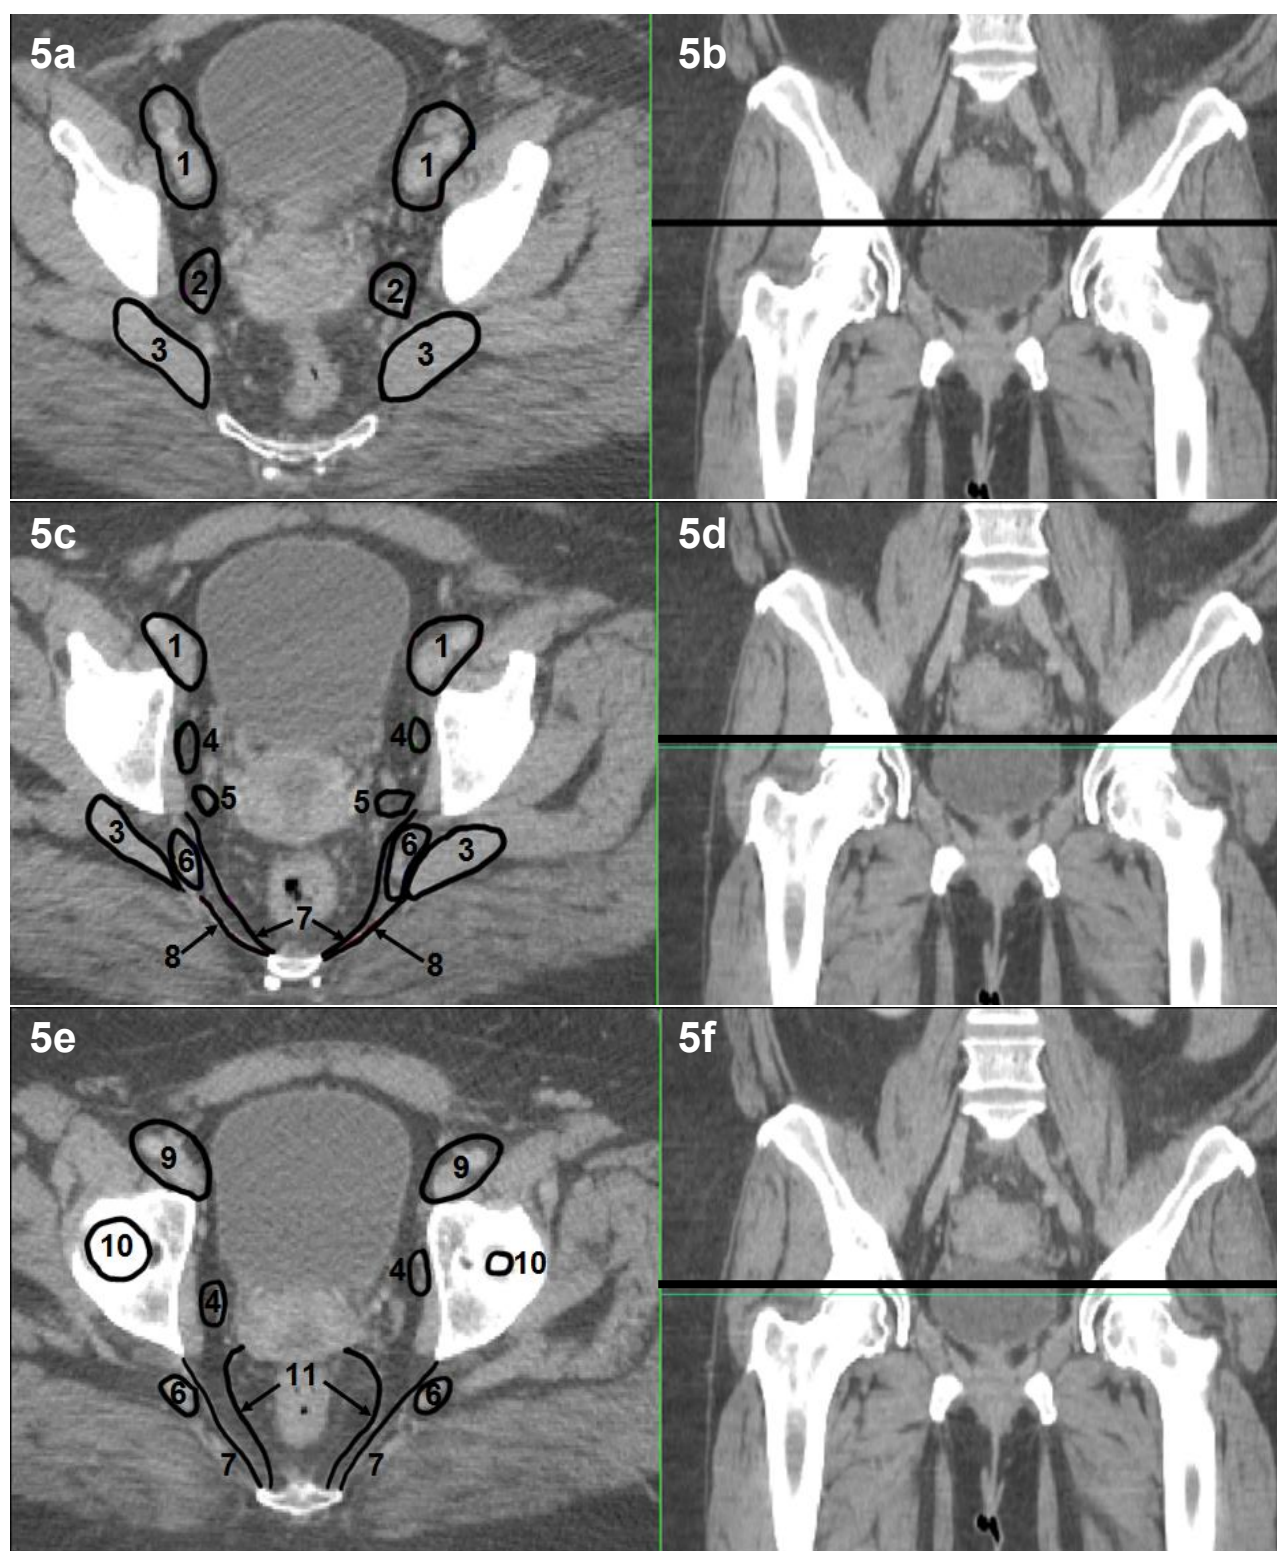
Transverse pelvic CT images (a,c,e) with the corresponding level shown on the coronal images (b with a, d with c and f with e). Anatomical areas: 1=external iliac vessels; 2=junction of gluteal and internal iliac vessels; 3=piriformis muscle; 4=obturator vessels/infra-iliac region; 5=internal iliac vessels; 6=gluteal vessels; 7= sacrospinous ligament; 8=sacrospinous ligament; 9=inguinal vessels; 10=femoral head; 11=uterosacral ligaments
